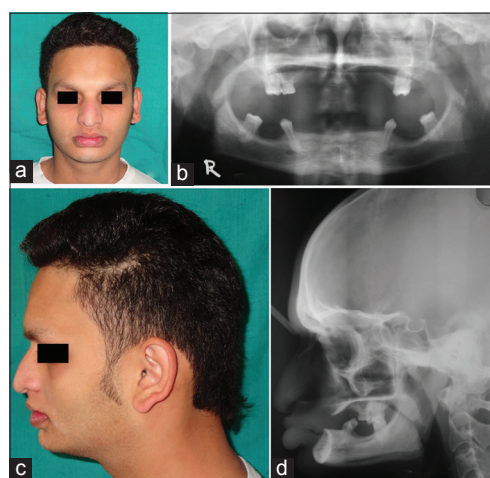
(a) Pre-treatment facial view showing average facial height; (b) pre-treatment panoramic radiograph showing severe loss of alveolar bone; (c) pre-treatment lateral profile view showing retruded upper lip, everted lower lip, and deep mentolabial sulcus; (d) pre-treatment lateral cephalograms showing Class III skeletal relationship, reduced value for upper anterior face height/lower anterior face height, reduced Frankfort mandibular plane angle, SNA and ANB angle, skeletal concavity as evident by NAPog measurement, reduced nasolabial angle, and deep mentolabial sulcus
